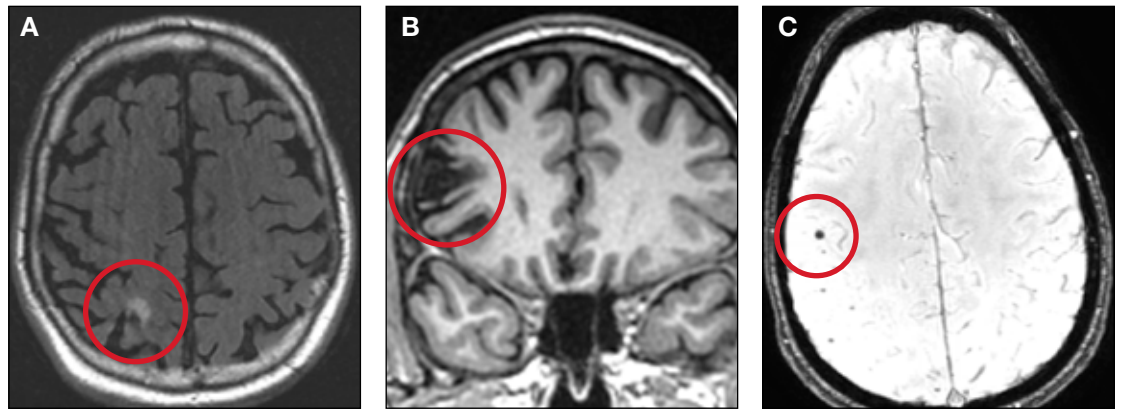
A, MRI showing contusion in right parietal cortex associated with prior traumatic brain injury. B, MRI showing encephalomalacia in right frontal cortex associated with prior traumatic brain injury. C, MRI showing hemosiderin deposition indicative of prior hemorrhage.*
